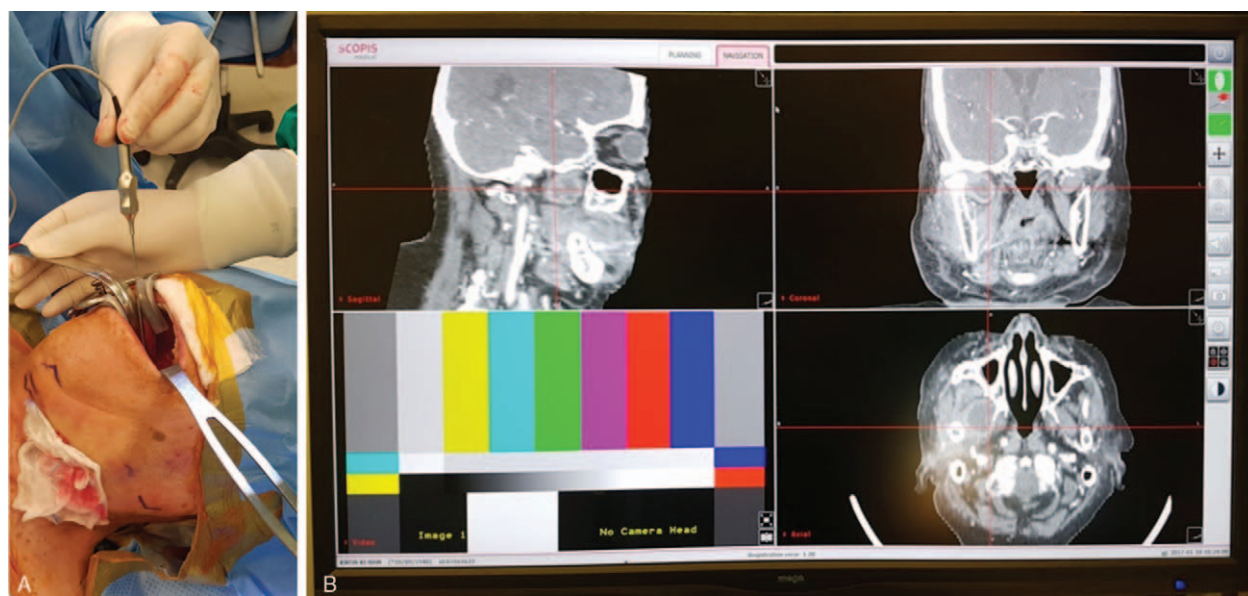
Computed tomography guided navigation assisted drainage procedure. (A) Navigation probes (seeker-tracker) was inserted into oral cavity. (B) The red lines crossing each other were accurately indicated the abscess pocket.
